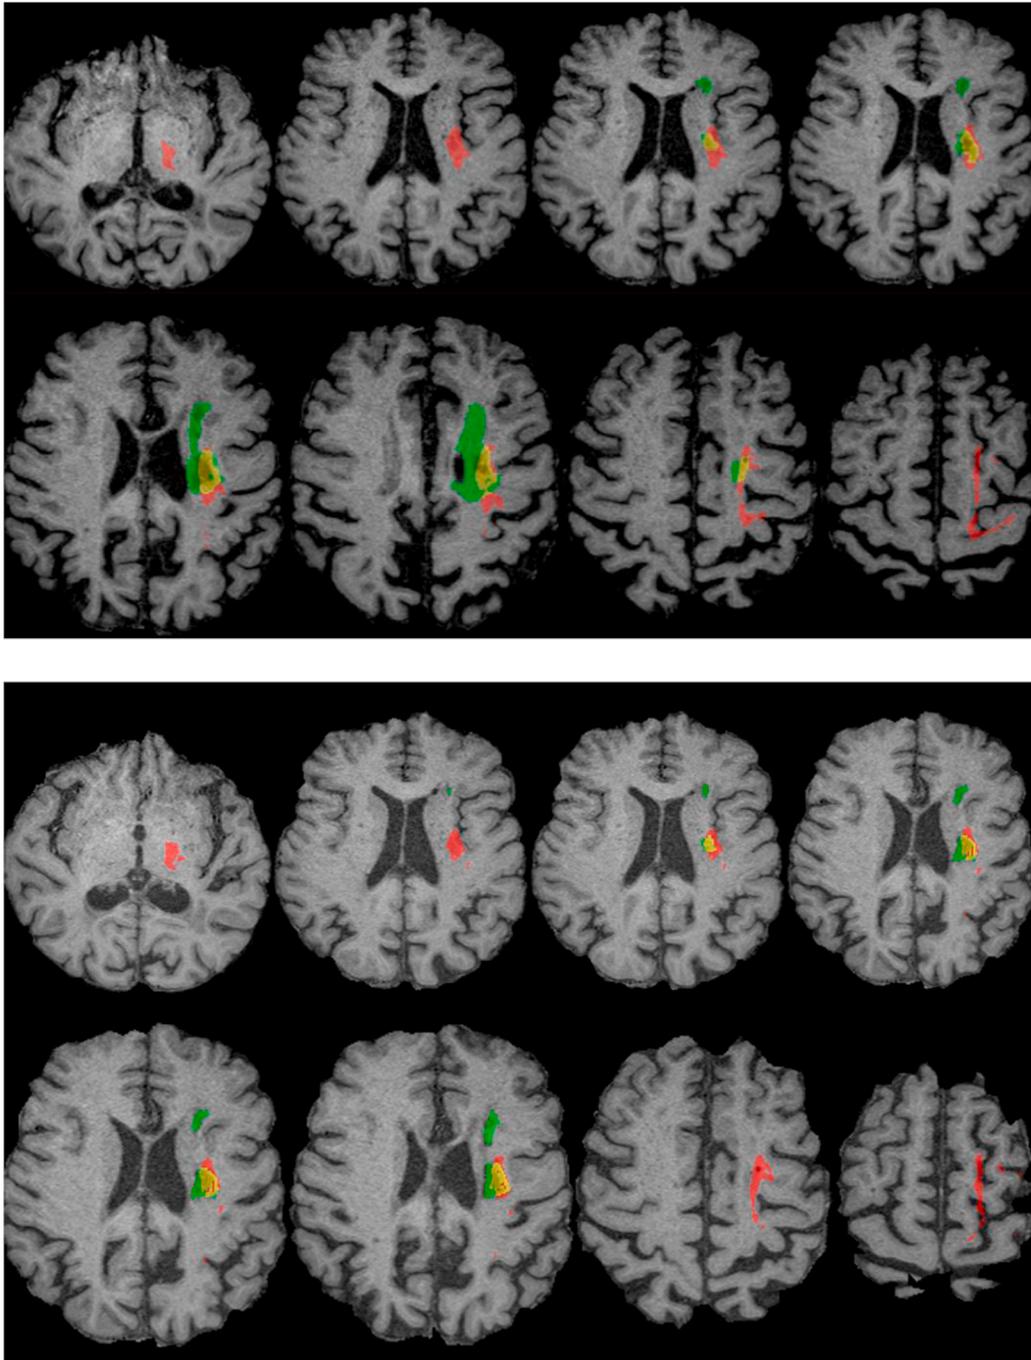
T1-weighted axial slices (from ventral on top left to dorsal on bottom right in each panel) showing thalamic projections (in red) that had passed through lesioned tissue (green) prior to the stroke. The region where the fibers could have been damage by the stroke is shown in yellow. Top Panel: Shows fibers that could have been disrupted by any part of the lesion. Bottom Panel: Shows where fibers would have been transected by the cystic component of the lesion.
